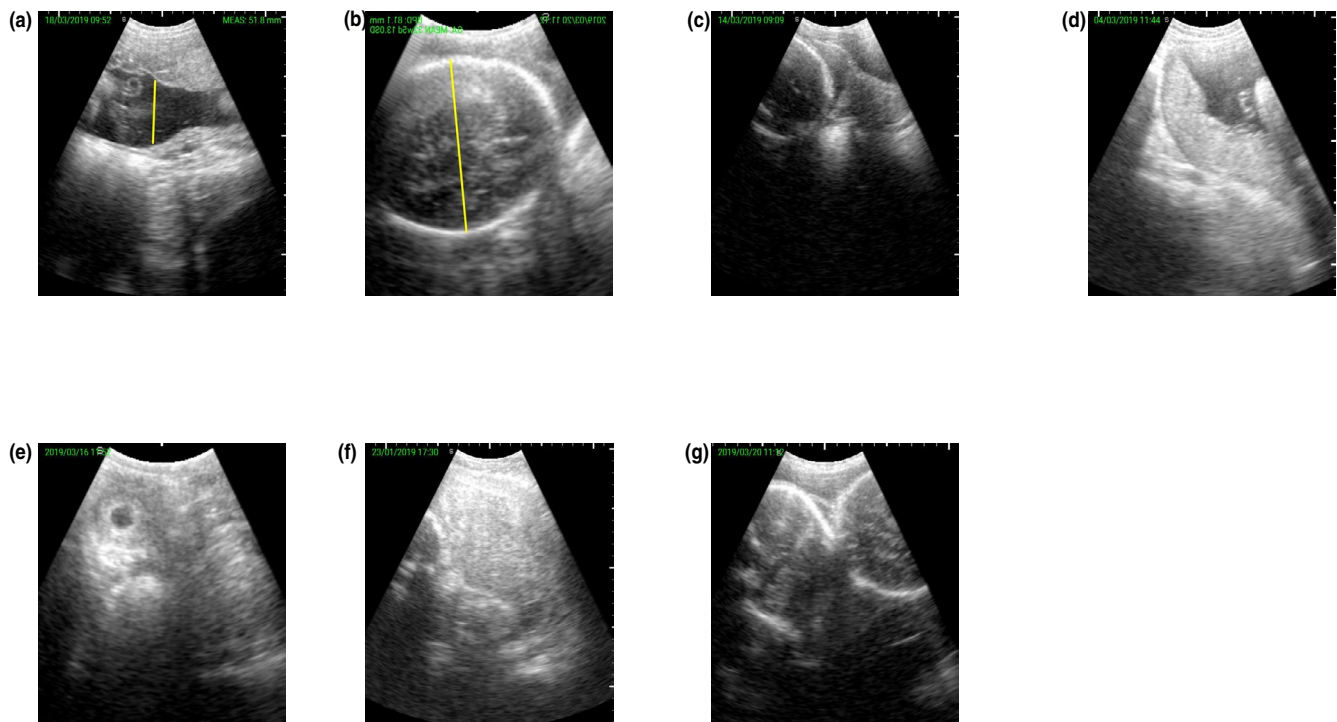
Representative images of the ultrasound findings recorded by the handheld ultrasound device. (a) Maximum vertical pocket of amniotic fluid. (b) Measurement of bi-parietal diameter. (c) Cephalic presentation. (d) Location of placenta. (e) Intrauterine pregnancy. (f) Retroplacental hematoma. (g) Multifetal pregnancy. No image of free fluid collection in the abdominal cavity was recorded. Fetal heartbeats were recorded as a video (Video S1)
